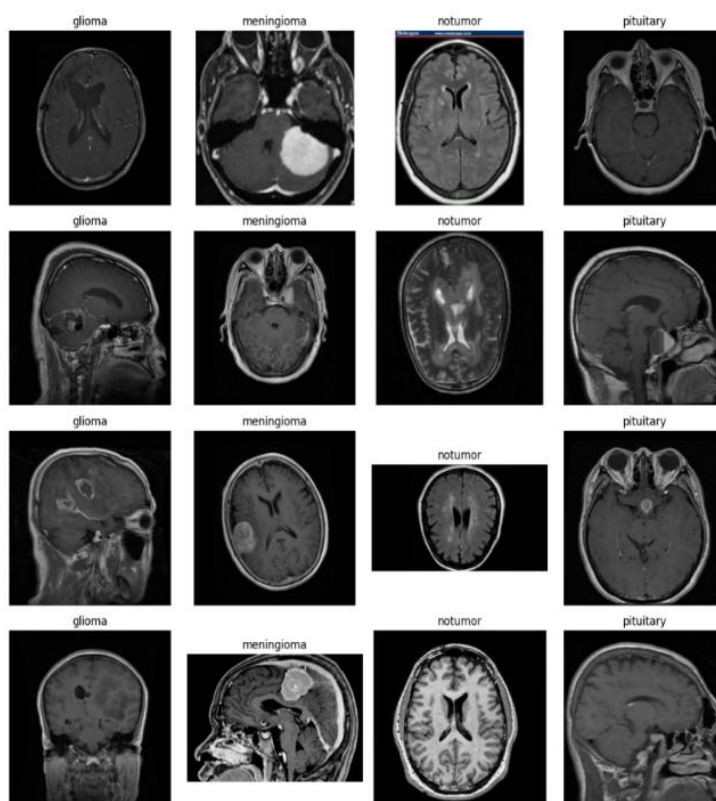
Sample images of testing brain tumor MRI dataset
